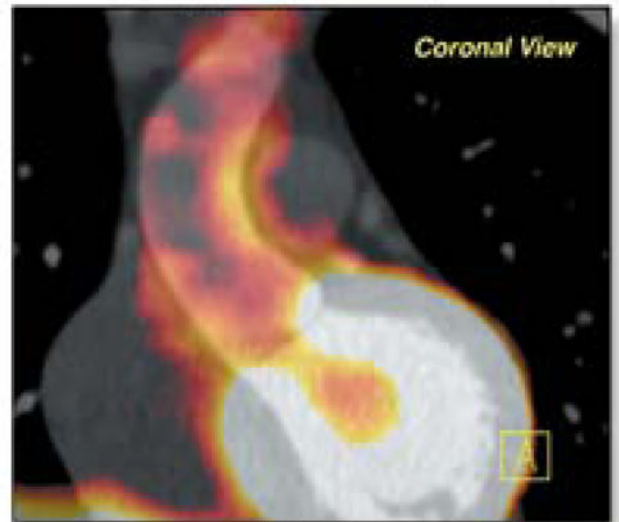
^{18}F FDG-PET/CT Aortic Imaging in HIV (78)
